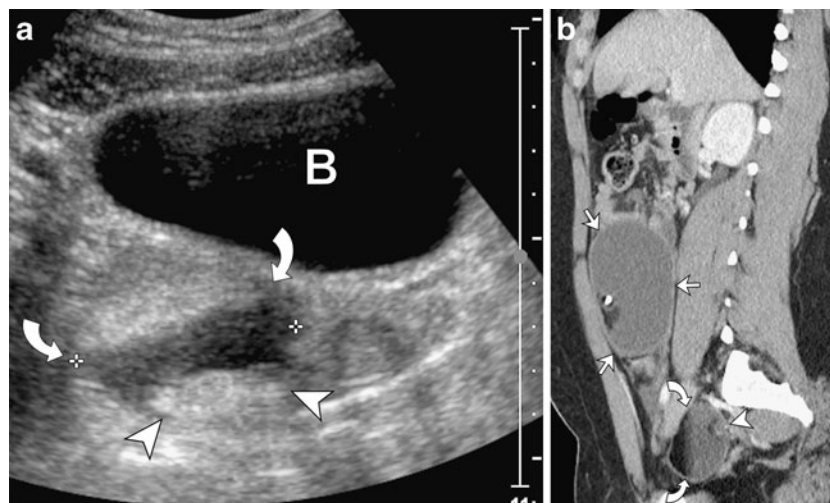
Bilateral mature cystic teratomas showing fat-fluid levels in a 16-year-old with acute onset of left lower quadrant pain and emesis. On US a large left adnexal mass was seen (image not shown). a Parasagittal US scan through the right hemipelvis shows an additional 5-cm right adnexal lesion (*between calipers*) with a fat-fluid level (*curved arrows*) and a Rokitansky nodule (*arrowheads*). b Sagittal reformatted CT image confirms the appearance of bilateral mature
